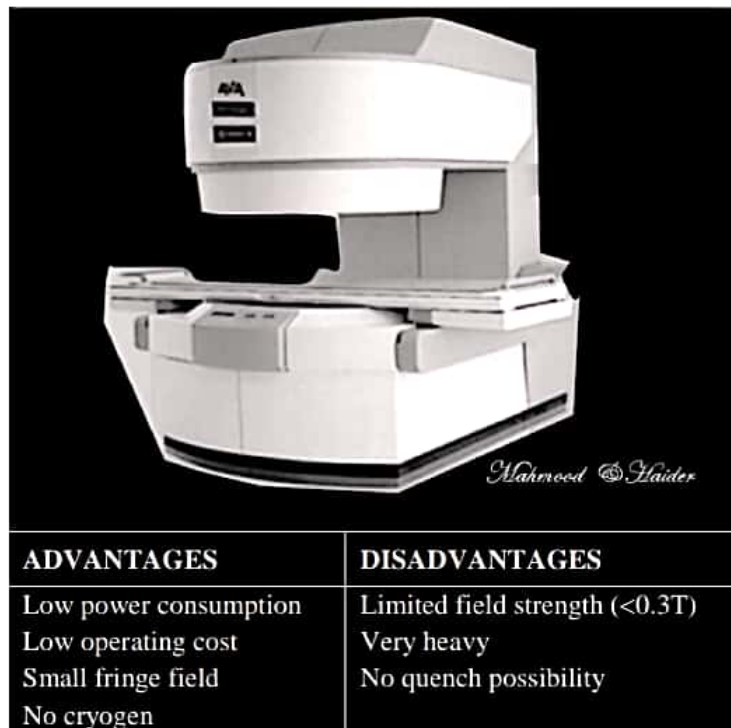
Open MRI system "OPER"
